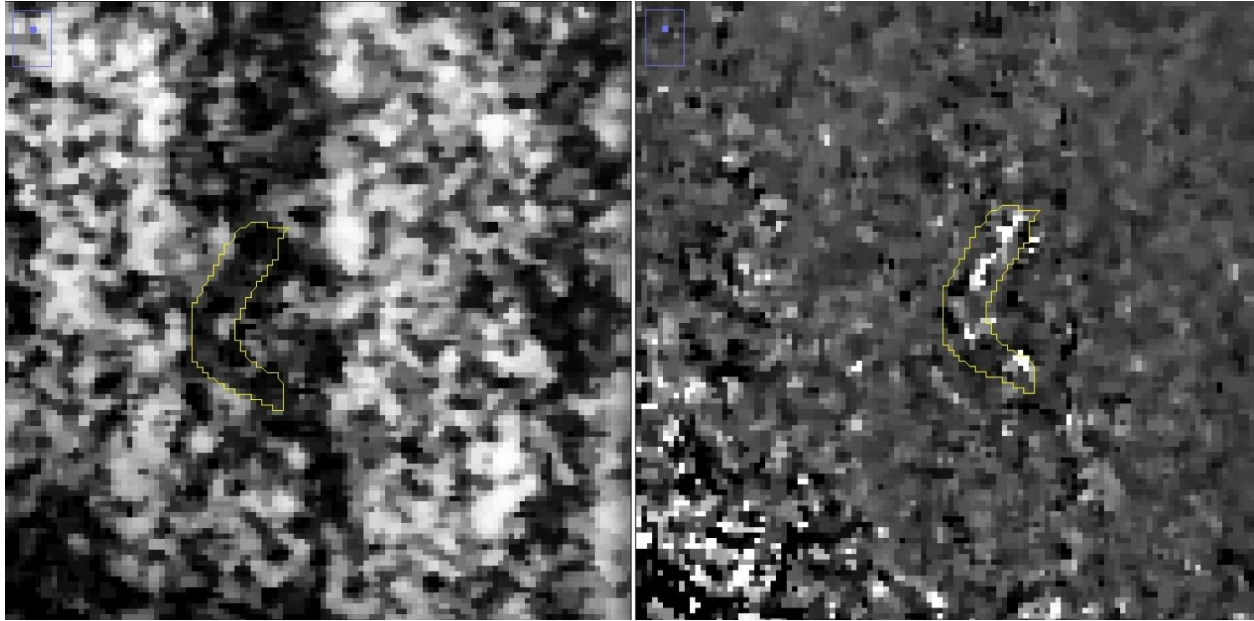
A magnified view shows that the regions of white Doppler signal correspond to the dark open spaces within the outflow vessel.
